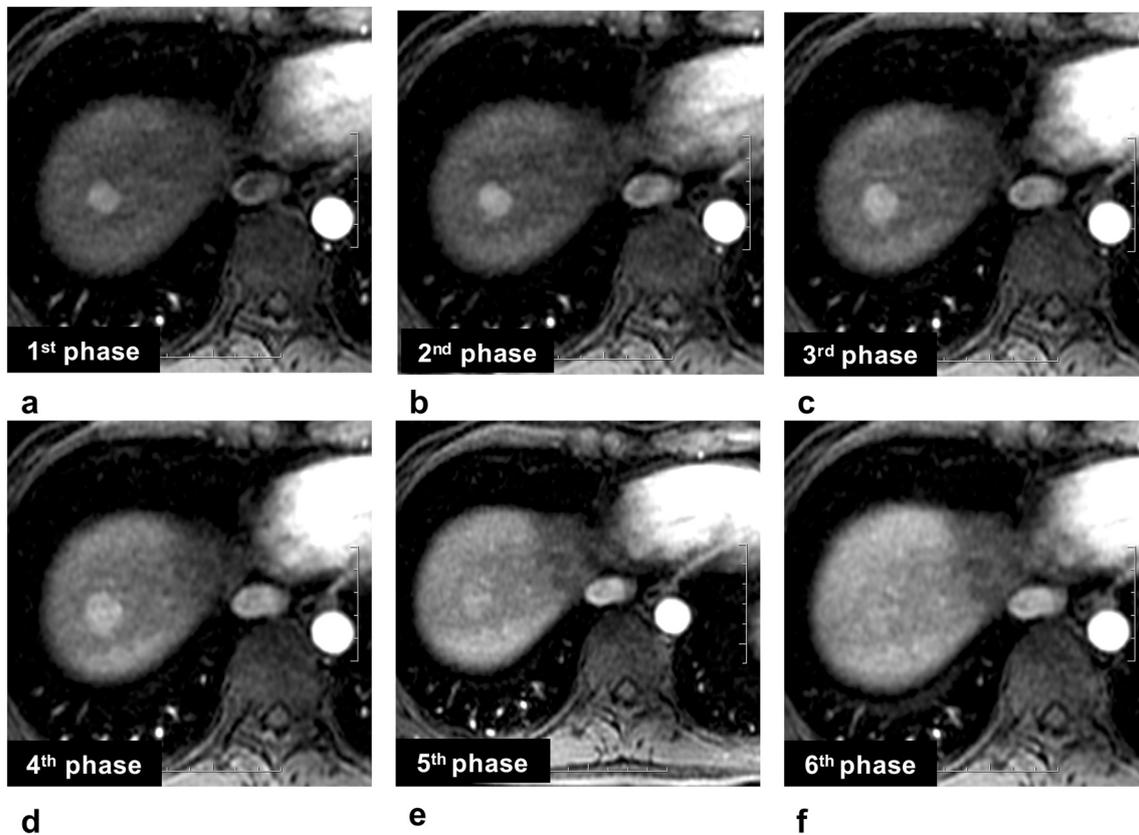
A 53-year-old man with hepatocellular carcinoma underwent gadoxetic acid disodium-enhanced liver MR images. The 1st to 6th multiple arterial phase (a–f) images of gadoxetic acid disodium acquired at 20 s, 23 s, 26 s, 29 s, 32 s and 35 s, respectively. Note no to minimal motion artifact was found from 1st to 6th phase, and the tumor showed typically enhancement pattern of “wash-in” from 1st to 4th phase (a–d), and typically enhancement pattern of “wash-out” from 5th to 6th phase (e–f).
